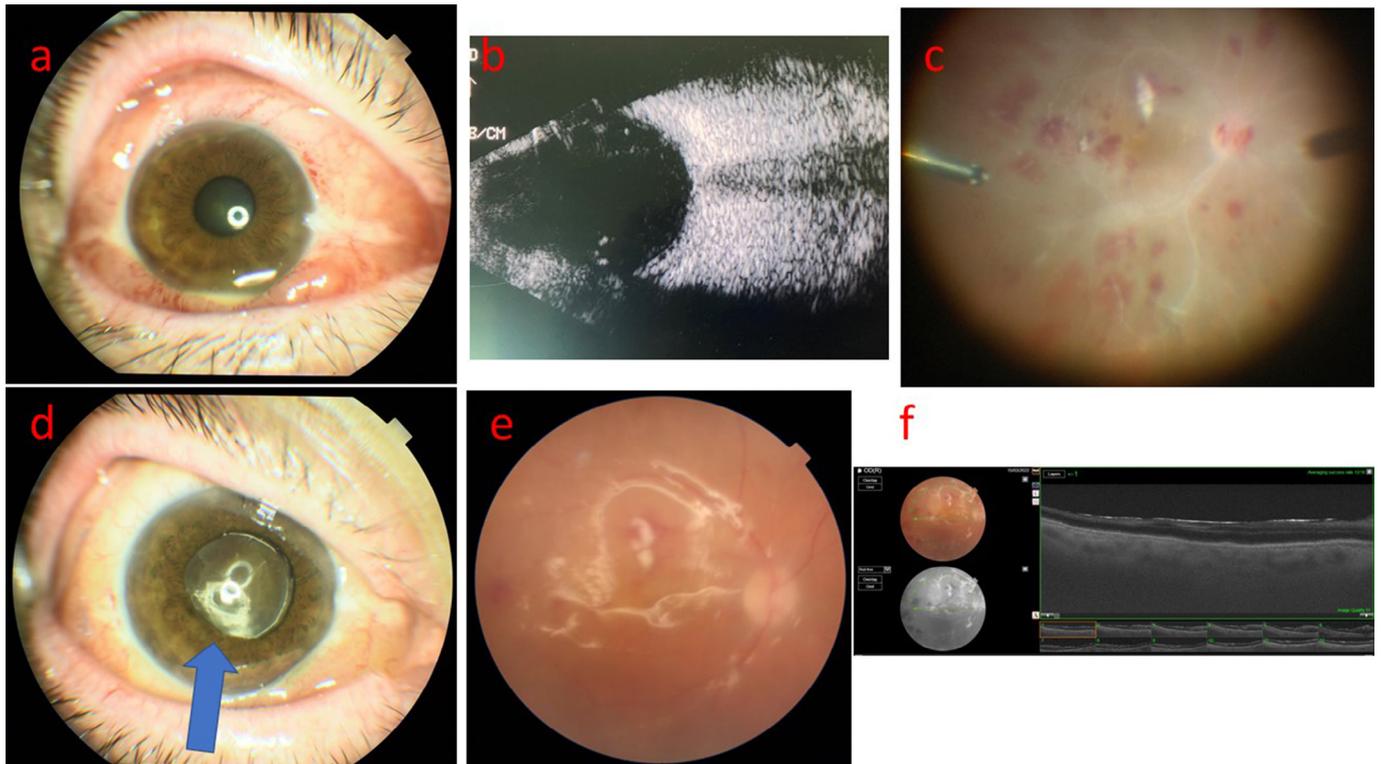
Images of a 65-year-old male patient who applied to our clinic with pain and vision loss in the right eye 4 days after intravitreal bevacizumab injection due to diabetic macular edema (Case 5). a- Right eye anterior segment image. There is hypopyon and grade 3-4 nuclear cataracts. The right visual acuity was hand movements. b- Right eye ultrasonography does not show any distinctive features except mild hyperechoic areas. c- In the intraoperative fundus image of the patient, there are findings disproportionate to the anterior segment findings and ultrasonography. Widespread arterial occlusion, hemorrhages, and infiltration areas. Methicillin-resistant *S. aureus* grew in the vitreous culture of the patient. d- Anterior segment image at 3 months after combined PPV and phacoemulsification. There is an inferior posterior synechia. e- In the fundus image in the 3rd month, blood flow was restored in the arteries of the eye under silicone, and hemorrhages and infiltration areas regressed. f- Fundus is flattened in the OCT image. Right vision level 0.16 decimal with correction.
